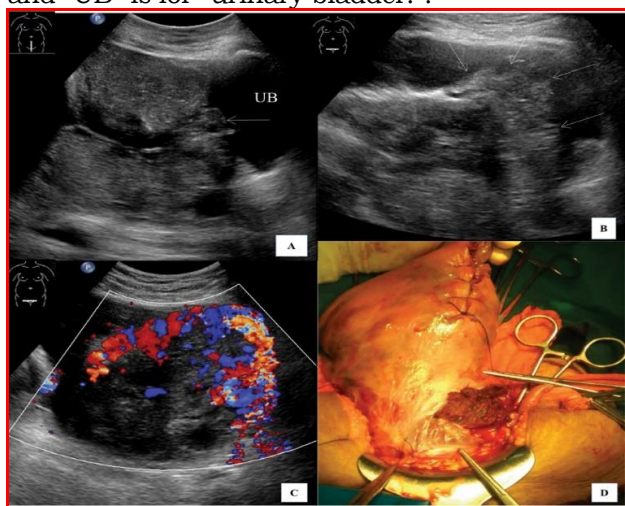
A 29-year-old woman who had two prior cesarean sections displayed signs of acute placental hemorrhage. (A) The trans abdominal sonography (TAS) image clearly shows an exophytic mass that is echogenic and has invaded the uterine base (UB) (arrow). The myometrium, uterine serosa, and bladder wall are not visible in this image. (B) The exact location of the invasion on the left side of the midline can be seen in the axial image at the same level. (C) The uterovesical interface displays significant hypervascularity in the color Doppler image of B. (D) This image was taken during the operation and shows the placenta as an exophytic mass that is sticking out from the front of the lower uterine segment and into the serosa. The acronyms "CS," "TAS," and "UB" stand for "urinary bladder" and "cesarean section," respectively.
